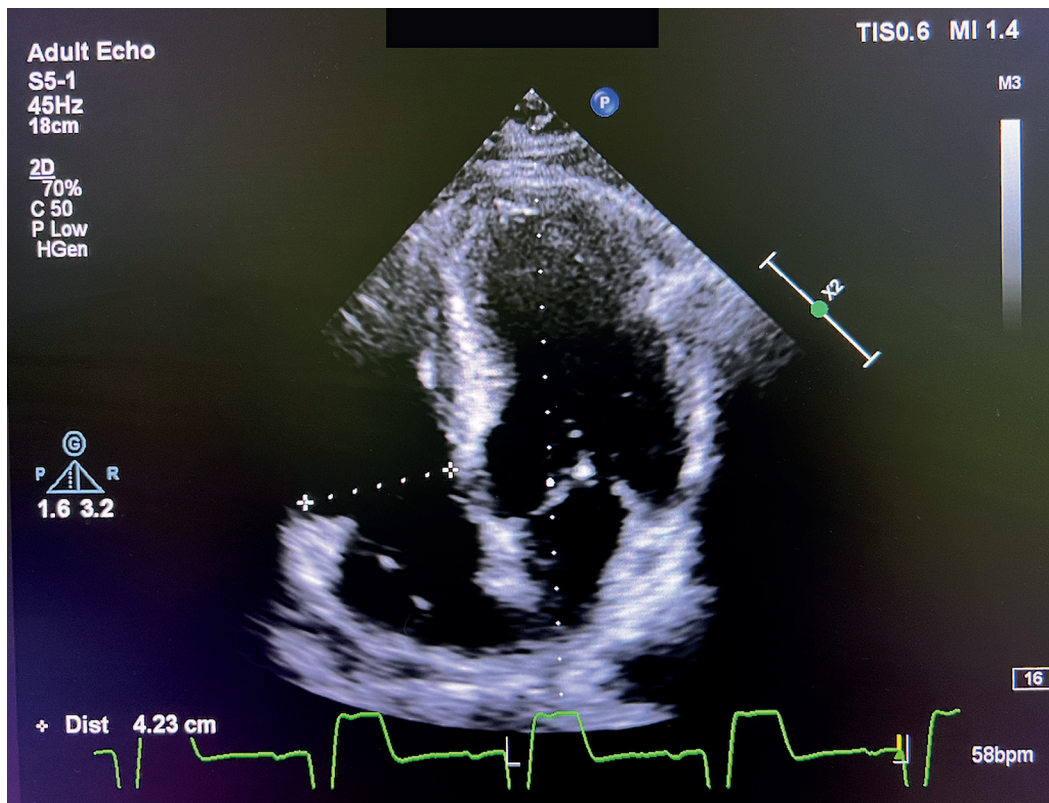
Echocardiographic image after interventricular septal myectomy in a patient with hypertrophic cardiomyopathy. Anonymized material; patient/author consent obtained for use of the figure
